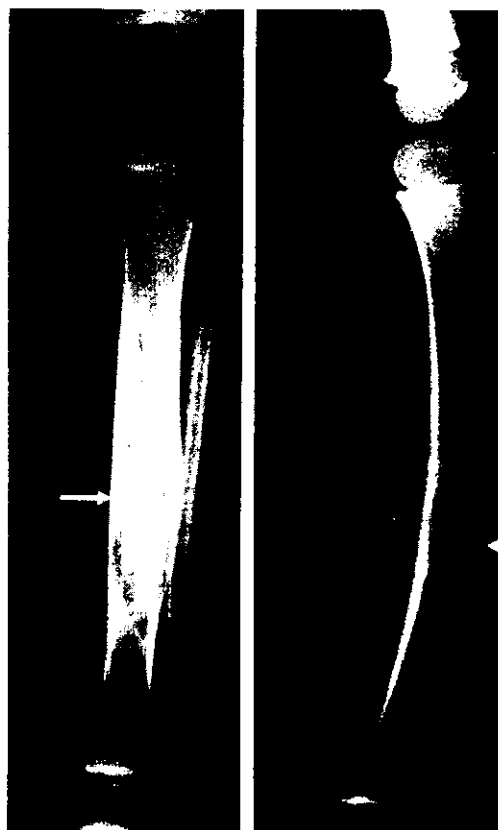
Case 3. AP and lateral roentgenograms showing a large osteolytic multilocular lesion involving the midshaft of the tibia. The anterior cortex is thinned and slightly expanded with bowing of the tibia.
